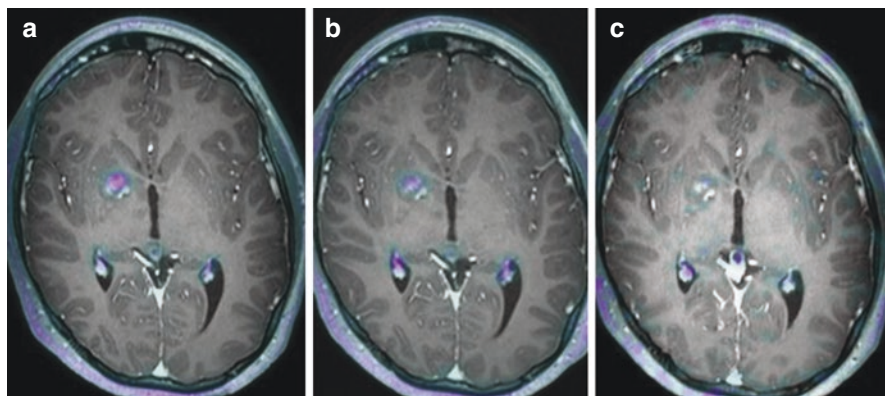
An 18-year-old man with a low-grade glioma. Baseline (a) and postchemotherapy scans (b, 2 months; c, 6 months). Magnetic resonance image shows similar size among the three examinations but with a decrease in SUVmax/mean in ^{18}F -Choline
